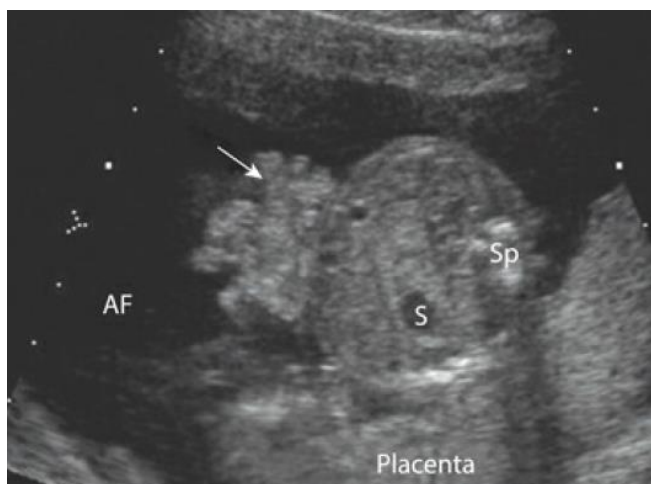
Ultrasound image of gastroschisis (arrow). AF, amniotic fluid; S, fetal stomach; Sp, fetal spine.
